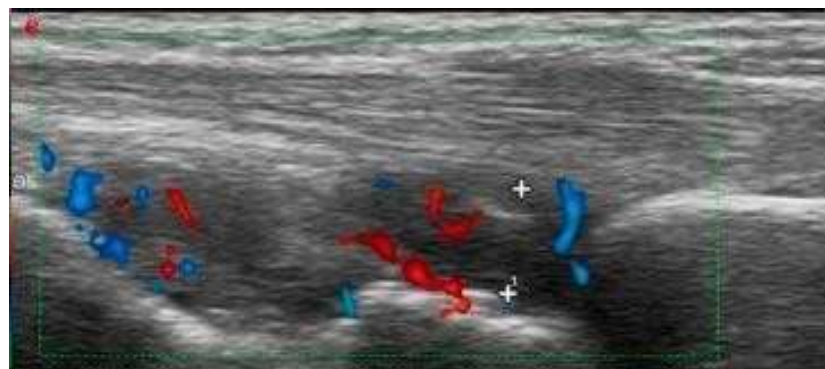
USG grayscale with colour Doppler image of 60 yrs old female RA patient showing increased vascularity at MCP joint suggesting synovitis
